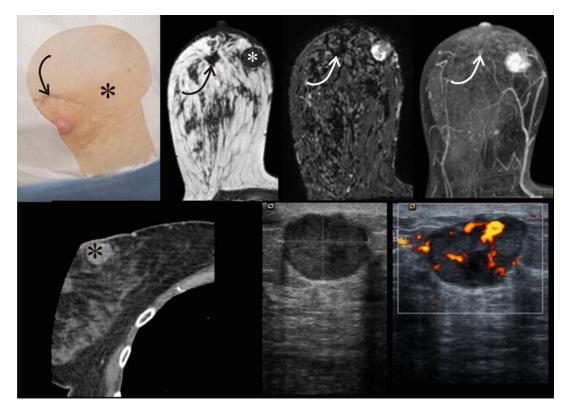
Cryotherapy for repeat local recurrence guided solely by US – planning: A 56-year-old woman with her third recurrence of invasive ductal carcinoma in the right breast, following two prior lumpectomies, radiation therapy, and chemo-hormonal therapy. *Top row:* Left clinical image shows periareolar skin retraction from prior lumpectomy site (*curved arrow*) and adjacent underlying tumor (*). Prone axial T1, T2, and MIP 3T-MR images show retraction from the previous surgical scar (curved arrows) and no T2 signal or enhancement. Conversely, the medial tumor (*) shows high T2 signal and distinct
